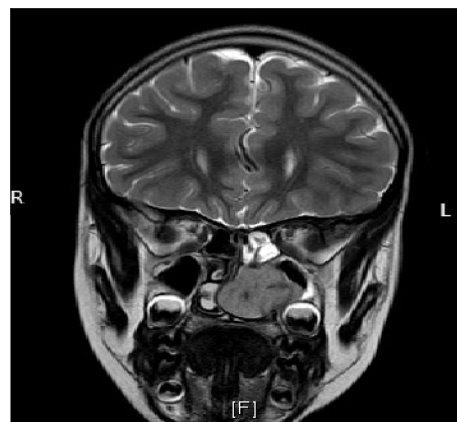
MRI T2 image in coronal view.
